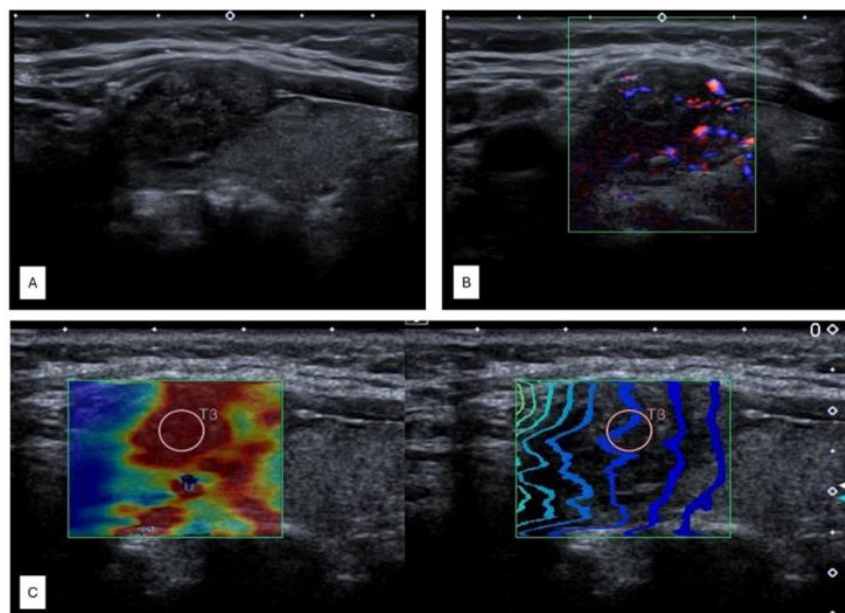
A) Thyroid ultrasound. B) Thyroid Color Doppler. C) Thyroid shear wave elastography.
